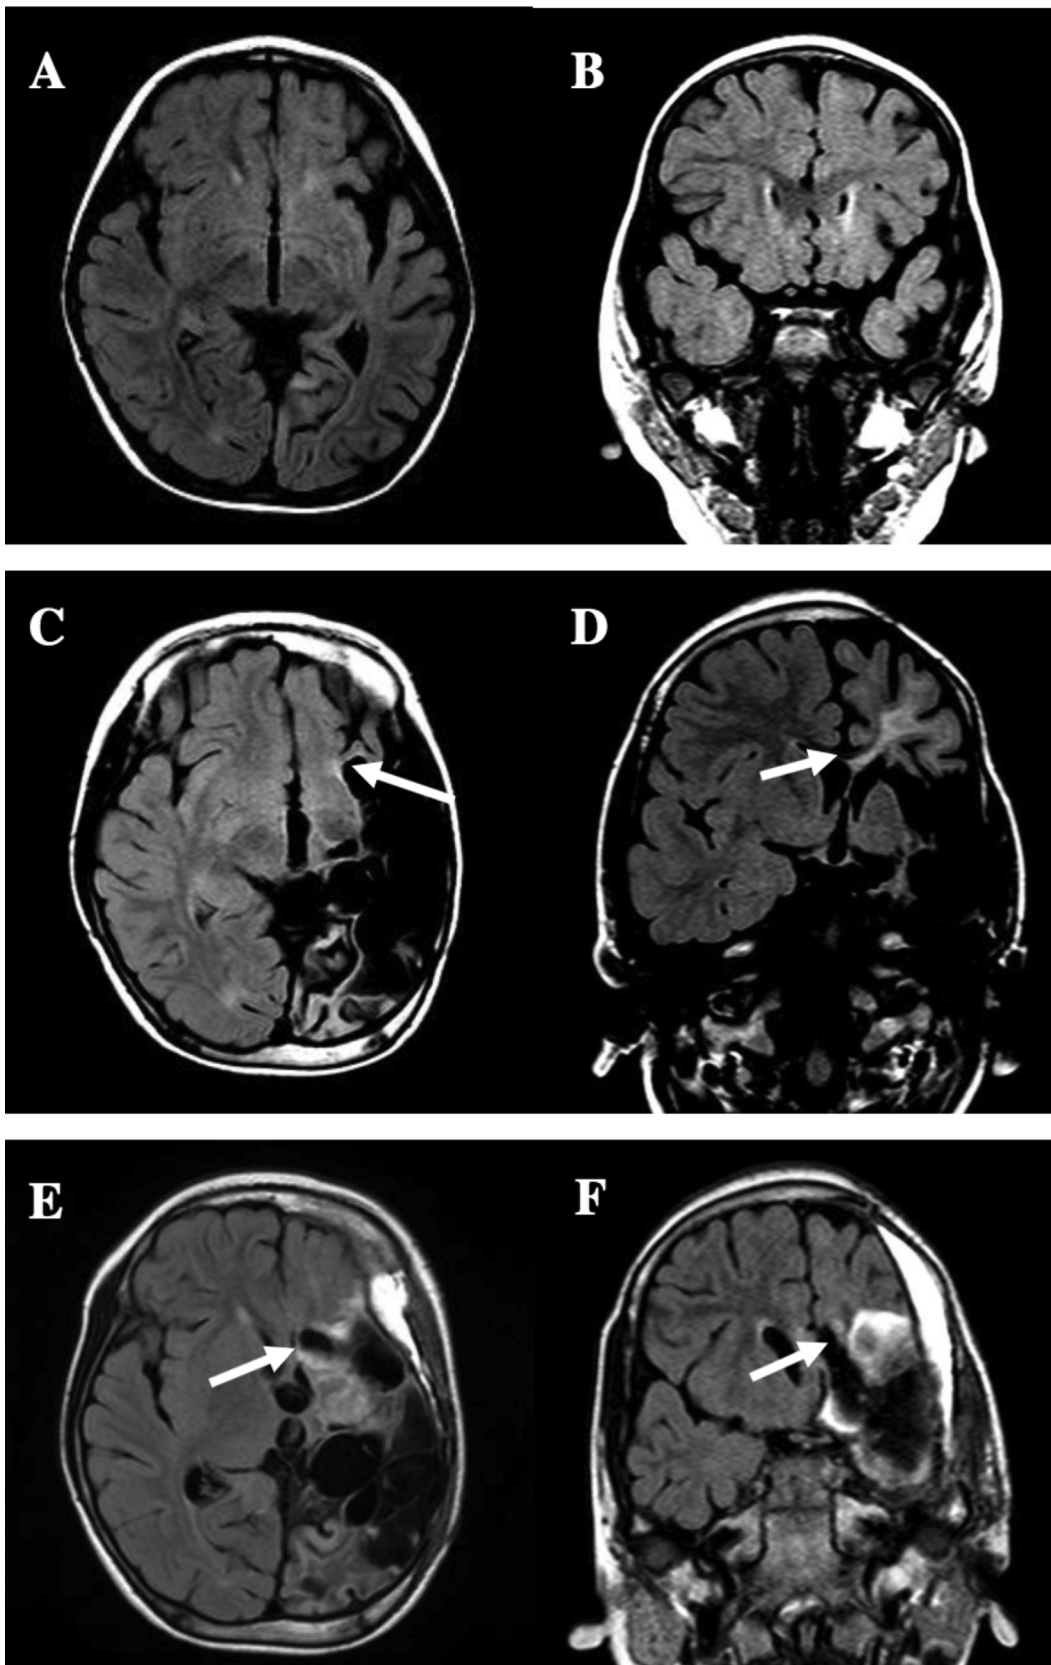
MRI obtained before and after hemispherectomy. Preoperative FLAIR in the axial plane (A) and the coronal plane (B). Incomplete disconnection at the frontal base (white arrow, C) and corpus callosum (white arrow, D) six years after primary hemispherectomy. Complete disconnection at the frontal base (white arrow, E) and corpus callosum (white arrow, F) two weeks after secondary disconnection.
